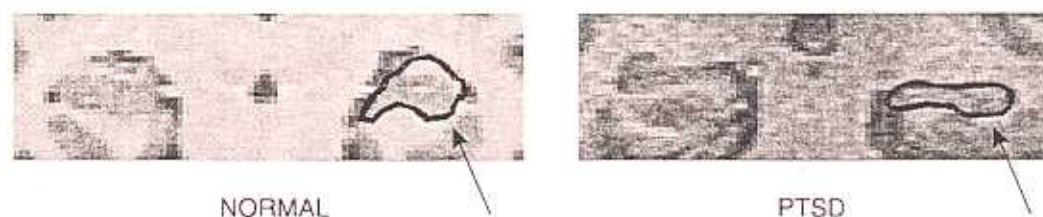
MRI of the hippocampus in a normal individual and a patient with PTSD. There is a visible reduction in hippocampal volume in the patient with PTSD.
